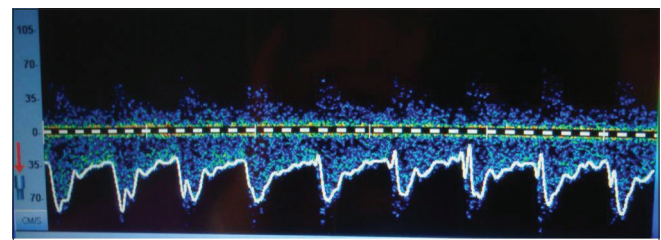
The transcranial Doppler waveform showing anterior cerebral artery, identified by the characteristic tracing in downward direction
